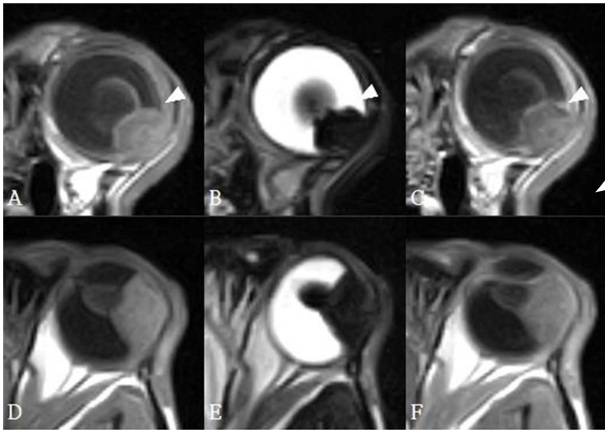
Ciliary body mass by magnetic resonance imaging. (A) Transverse precontrast T1-weighted, (B) T2-weighted, (C) post-contrast T1-weighted, (D) Dorsal oblique precontrast T1-weighted, (E) T2-weighted, and (F) post-contrast T1-weighted images. A well-defined, smoothly marginated, triangular-to-oval-shaped mass with signal hyperintensity on T1-weighted and signal hypointensity on T2-weighted magnetic resonance images of 1.1 cm × 1.1 cm × 1.5 cm (W × H × L) was observed at the left ocular ciliary body (arrowhead). The mass was located from the anterior chamber to the posterior chamber, originating from the ciliary body. The lens was displaced medially by mass effect. There was slight irregular contrast enhancement throughout the mass.
